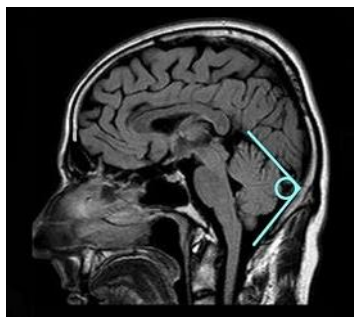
Sagittal FLAIR image demonstrating the tentorium cerebelli slope is shown as the angle between the blue lines
